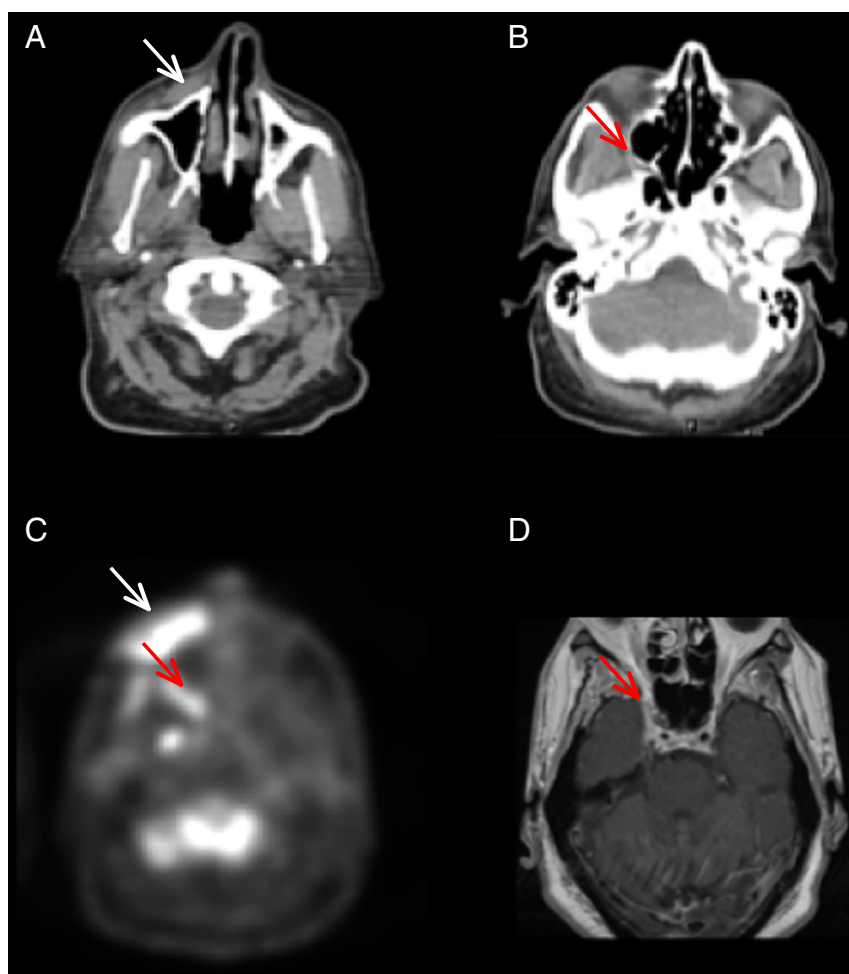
Radiographic example of perineural invasion. Axial computed tomographic (CT) image of squamous cell carcinoma of the malar cheek, with perineural invasion (PNI) of the right maxillary nerve (cranial nerve [CN] V₂), revealing the following: (A) Primary tumor (white arrow) and (B) thickening of the maxillary nerve, consistent with PNI by cancer (red arrow); (C) axial positron emission tomographic image reveals hypermetabolic lesions corresponding with the primary tumor (white arrow) and PNI in the maxillary nerve (red arrow); and (D) axial T1 postcontrast magnetic resonance image shows PNI in the maxillary nerve (red arrow).
